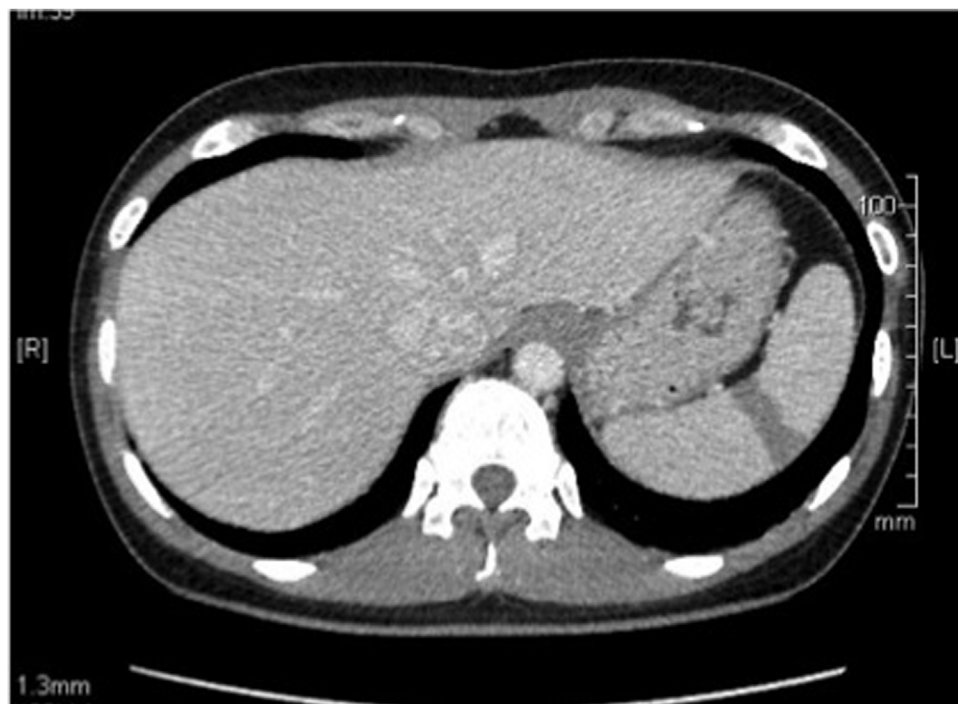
A contrast whole trunk computed tomography scan revealed low-density attenuation in the spleen.
